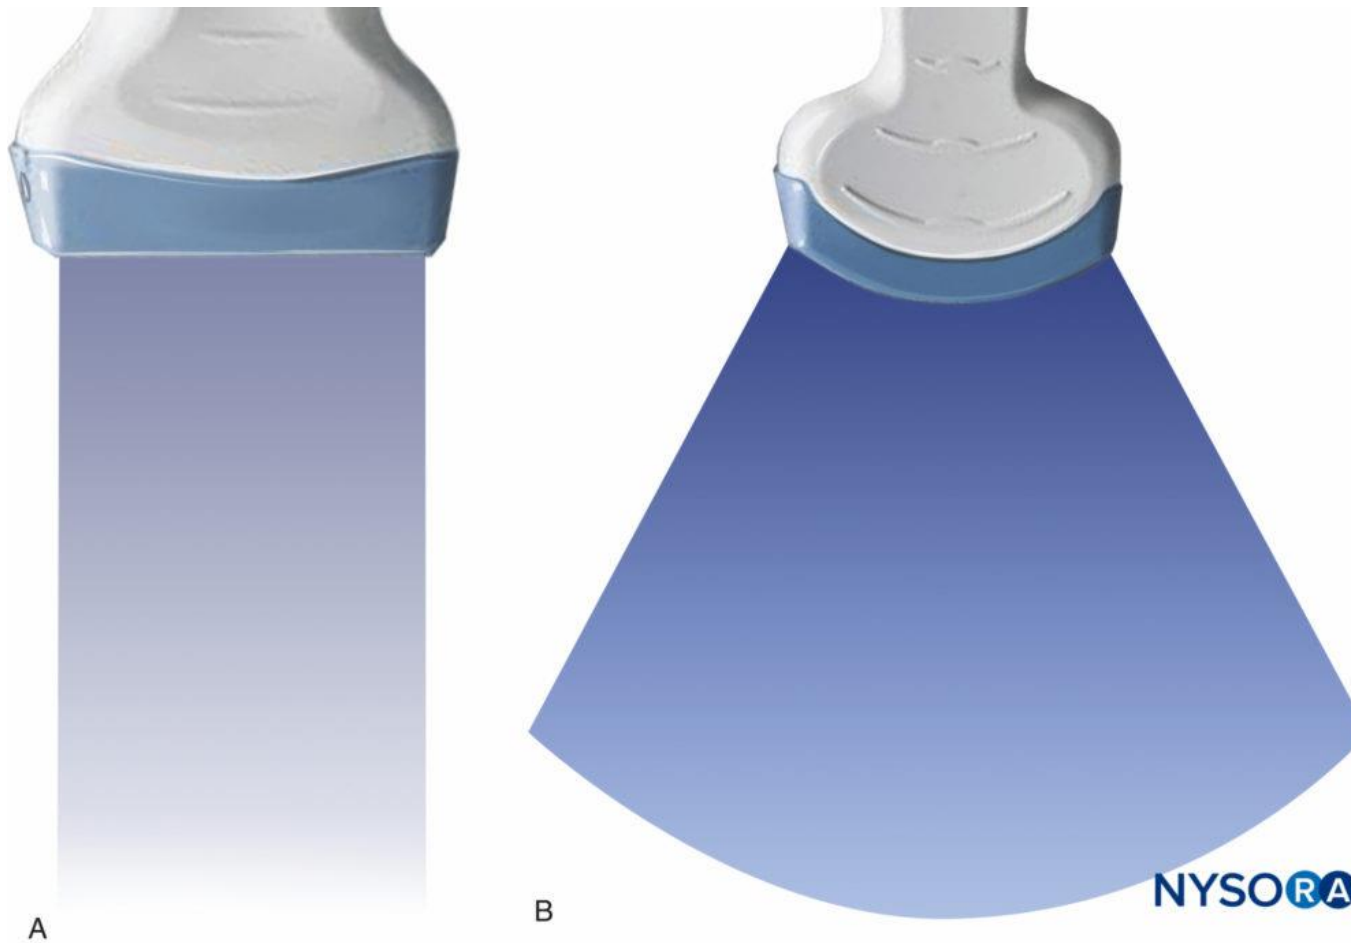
A: Rectangular scan field given by linear transducer. B: Arc-shaped scan field given by curved transducer. (Adapted with permission from Hadzic A: Hadzic's Peripheral Nerve Blocks and Anatomy for Ultrasound-Guided Regional Anesthesia, 2nd ed. New York: McGraw-Hill, Inc; 2011.)
